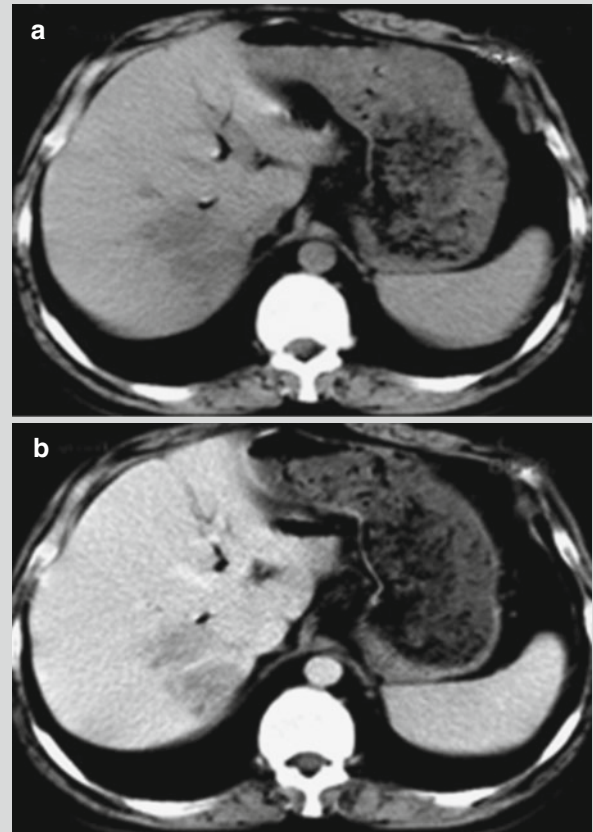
Hepatic lesions of visceral leishmaniasis. (a, b) Plain CT scanning reveals multiple flakes of foci with low density in the right hepatic lobe, with unclear boundaries. Contrast CT scanning demonstrates slightly enhanced foci still in low density
